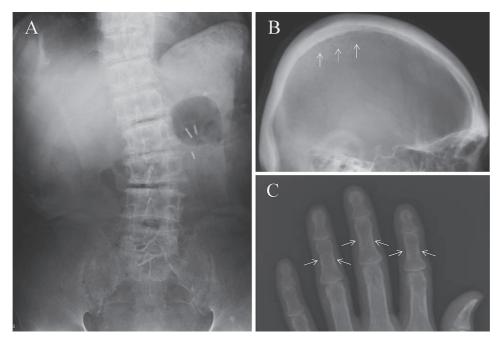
Bone survey by X-ray.
